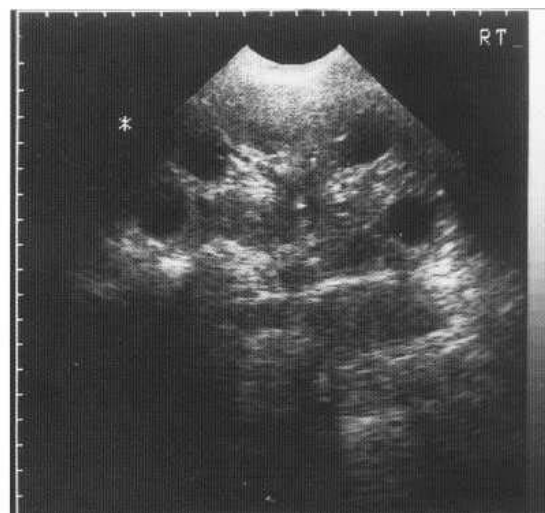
Ultrasound showing relatively early polycystic disease with multiple simple cysts demonstrable.
